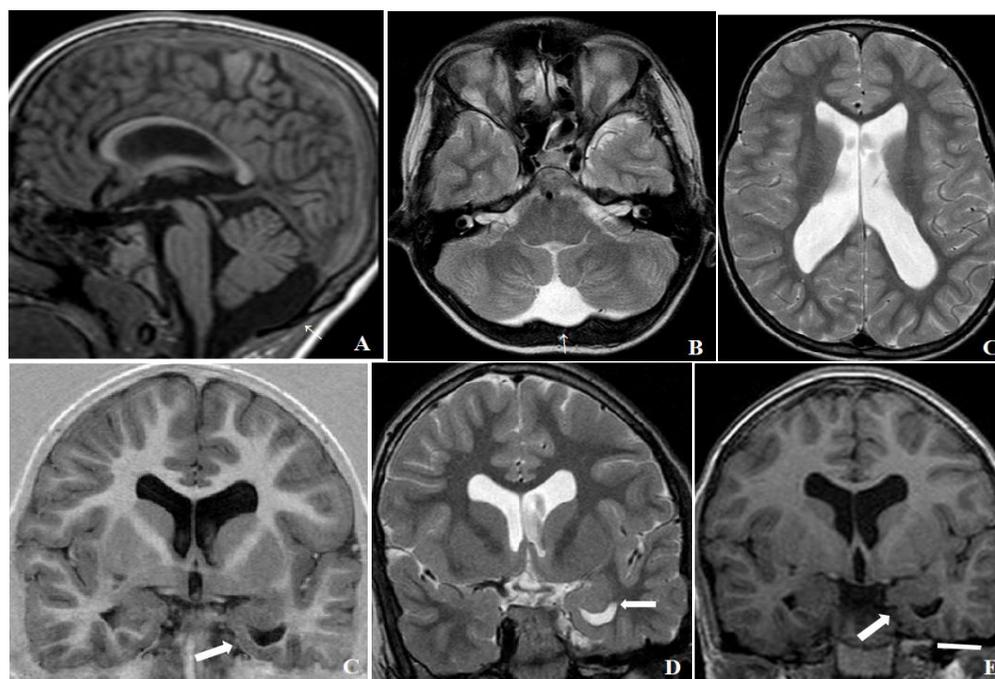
MRI results. Neuroimaging performed at 10 and 16 years of age showed essentially unchanged abnormalities. In the posterior fossa, the only abnormality was the presence of a voluminous retrovermian arachnoid cyst (small white arrows) (A, sagittal T1-weighted; B, coronal T2-weighted). The pathologic square-shaped lateral ventricles were diffusely and rather symmetrically enlarged, especially the frontal horns (B, coronal T2-weighted; C, axial T2-weighted). The left hippocampus showed an essentially absent subiculum fissure with abnormal uniform horizontalization of the parahippocampus and subiculum and progressive alteration of Ammon's horn folding (white arrowheads) (D and E, FLAIR T2-weighted; F, FLAIR T1-weighted); the left temporal lobe was smaller than the contralateral one, and the inferior temporal and entorhinal cortex also showed rather abnormal folding.
